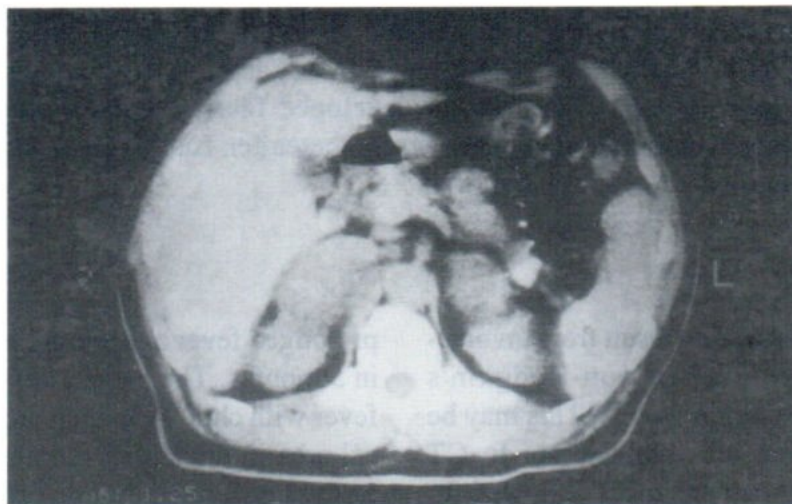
Unenhanced CT scan shows bilateral adrenal masses. The masses are slightly hypodense than renal parenchyma.
